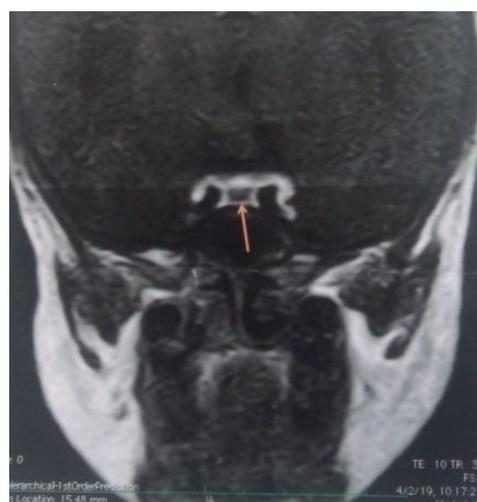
Magnetic resonance imaging (MRI) of the brain with the pointer showing the pituitary microadenoma.
